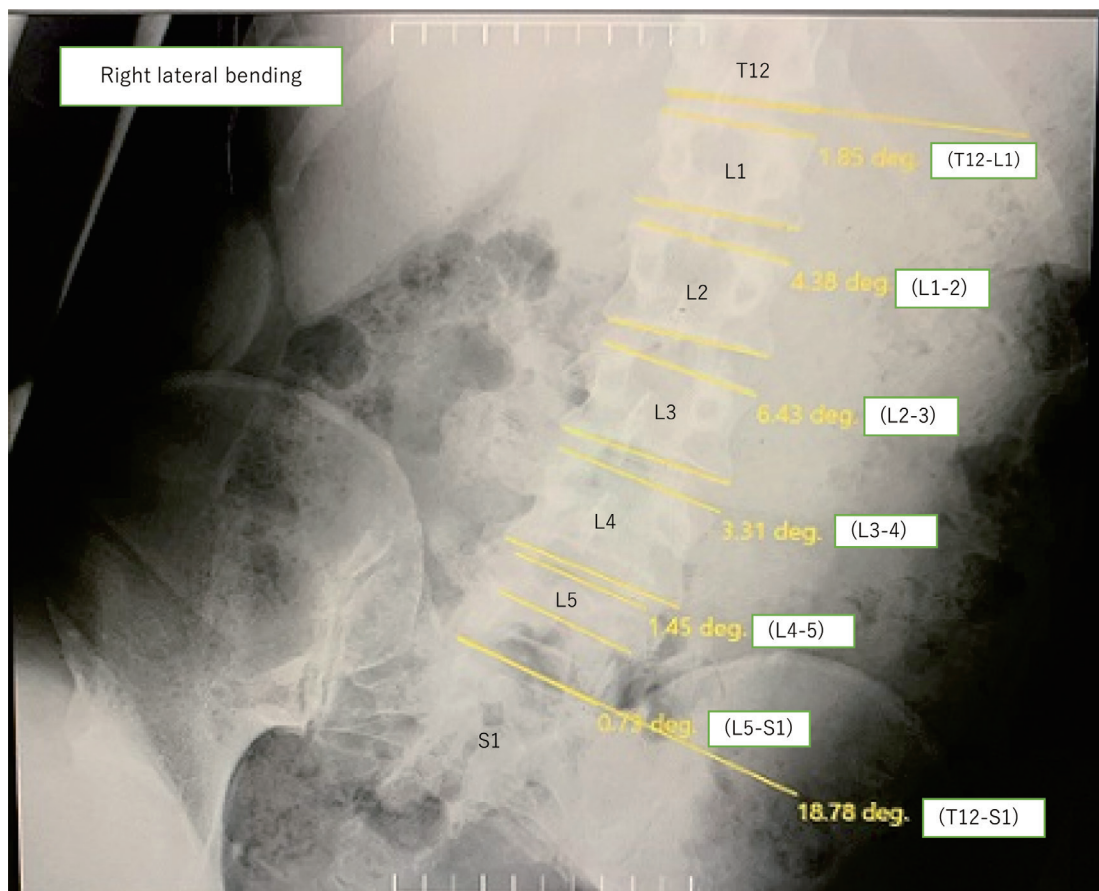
Radiograph of lumbar spine with lateral bending
